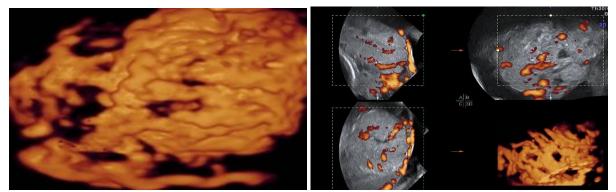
and Fig.14. 3D Power Doppler irregular placental vascularization
